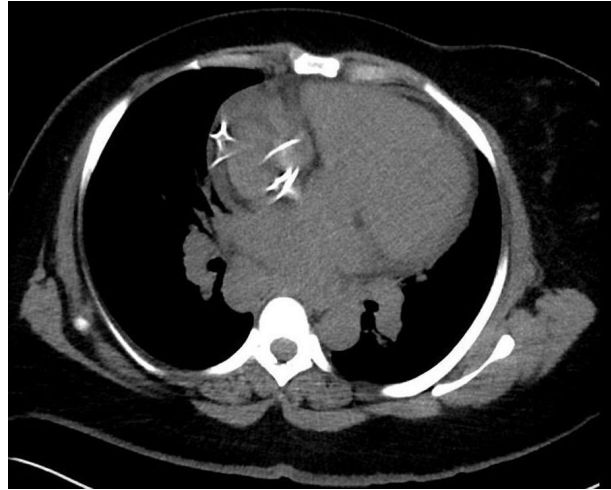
Computed tomography of the chest without contrast showing an enlarged right hilar lymph node.
